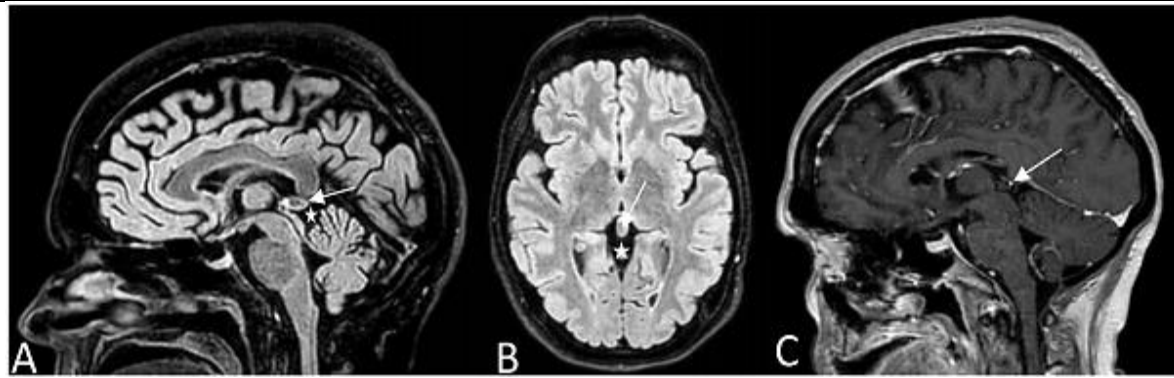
MRI study of the pineal cyst. (A, B) A hyperintense lesion in FLAIR sequences. (C) T1 contrast-enhanced sagittal image of the lesion. (A) The white arrow points to the cyst wall, which seems slightly hyperintense. (B-C) A white arrow shows a cystic lesion in the pineal area. The white star indicates the quadrigeminal cistern (Bichat's canal) that surrounds the pineal gland, the splenium of the corpus callosum, the quadrigeminal tubercles, and the superior surface of the cerebellar vermis (A-B).
